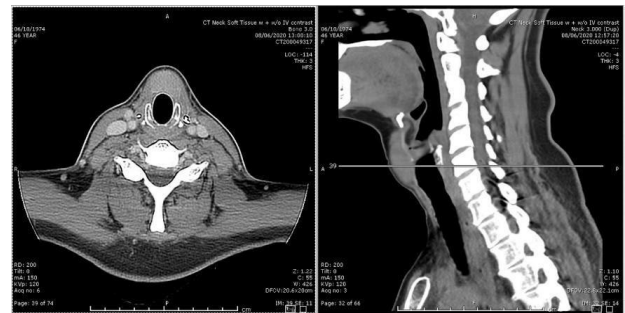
CT scan of the neck 2 years post-operatively from total thyroidectomy, transverse and sagittal views showing an enlarged midline mass inferior to the hyoid bone.
